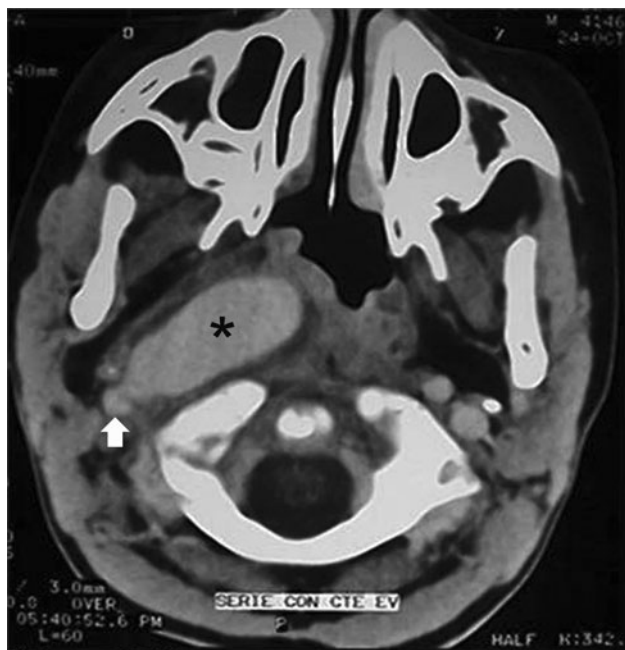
CT scan shows a pseudoaneurysm (*) from the internal carotid artery (arrow) displacing the oropharynx
